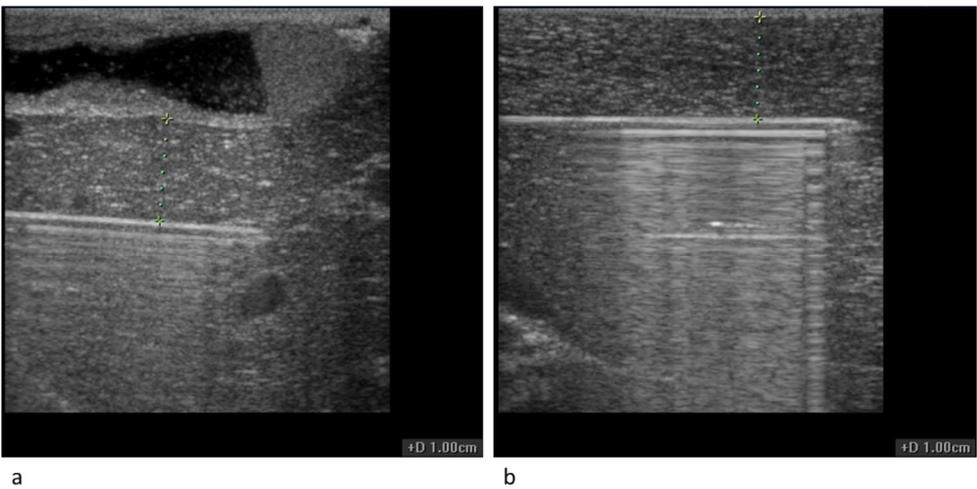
Ultrasonographs of an electrode inserted 1 cm apart from (c) the gallbladder and (d) liver surface. Electrodes were inserted parallel to the liver surface or gallbladder.
